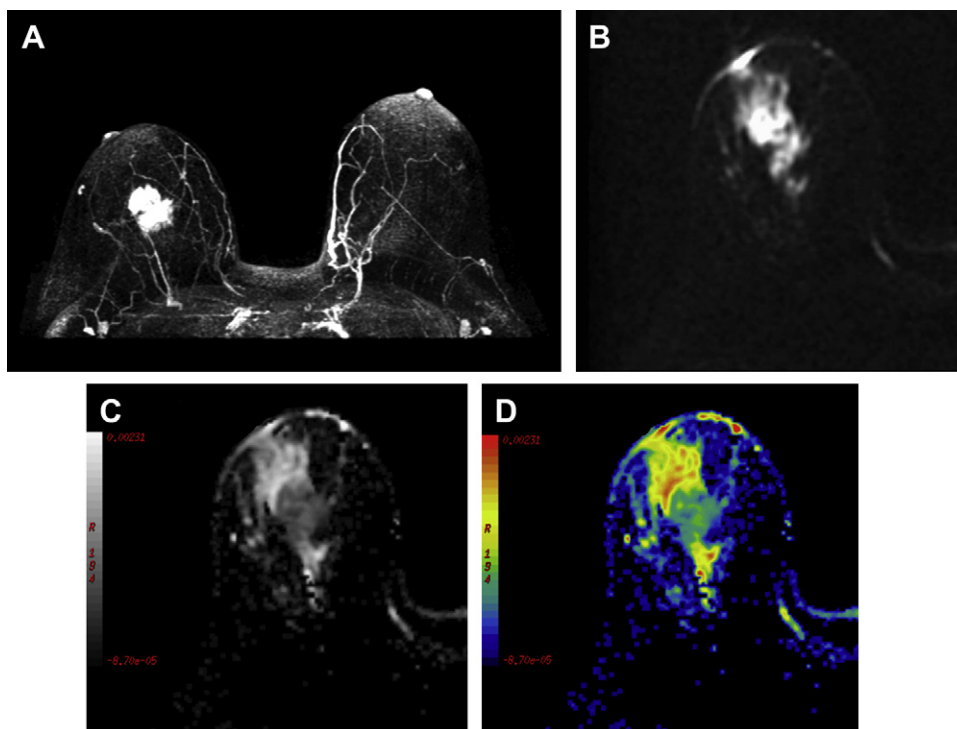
49-year-old woman with IDC of the right breast. (A) Axial maximum intensity projection of a contrast-enhanced T1-weighted three-dimensional spoiled gradient-echo image, first phase, subjected to subtraction technique. (B) Axial diffusion-weighted image. (C) Axial black-and-white and (D) colored ADC maps obtained using b-values of 0 and 750 s/mm² show enhancement of a highly suspicious mass, evident as increased loss of signal on the ADC black-and-white map and blue on the ADC colored map, which indicate restricted diffusion.
